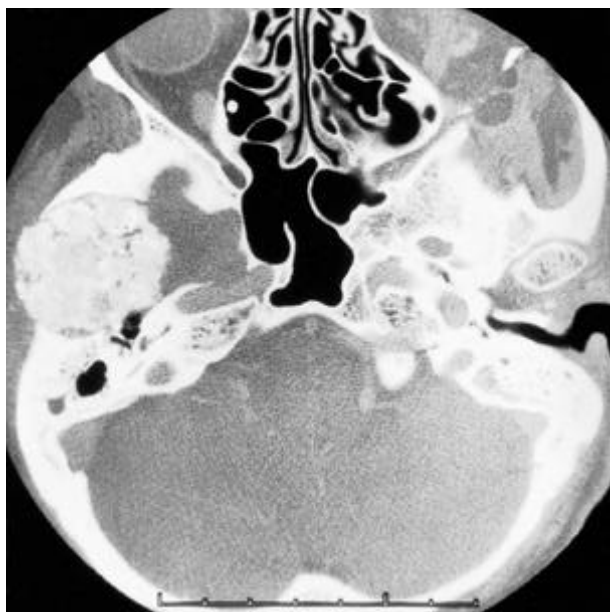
Post-contrast CT scan shows a heterogeneously enhanced, irregularly lobulated mass in the right temporal bone (case 4).
